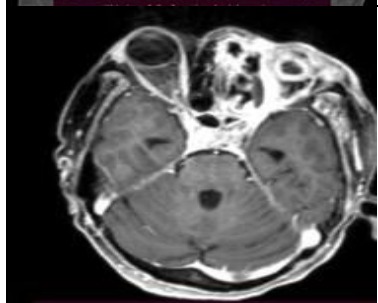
Contrast enhanced MRI showing orbital and cavernous sinus infiltration with lack of expected enhancement in left cavernous sinus.
